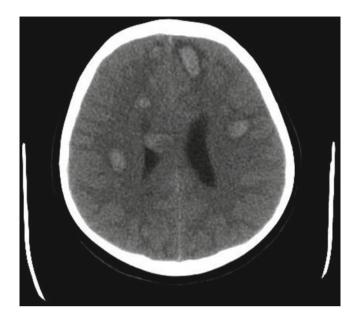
Computed tomography scan of a 13-year-old patient presenting with persistent malaise, fever, and weakness. Decreased sensorium developed in the child while awaiting evaluation in an EC. His white blood cell count exceeded 400,000/mL. The scan revealed multifocal cerebral hemorrhages with associated edema leading to clinical brain death several days later
